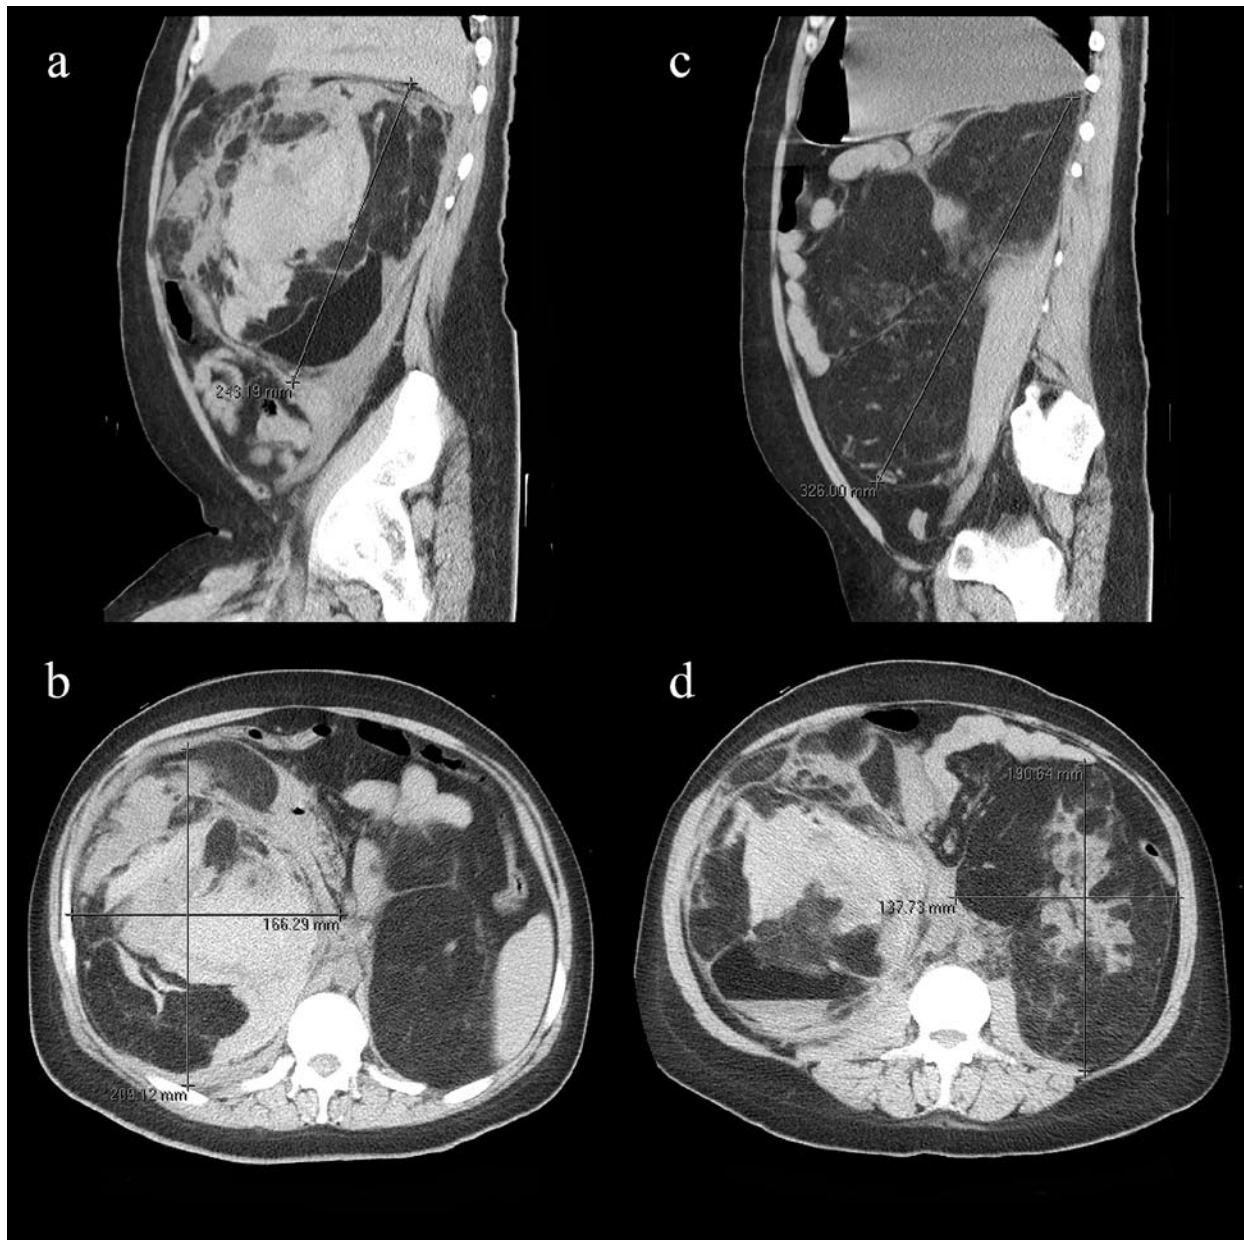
Non-enhanced axial and coronal CT images showing size of the masses
